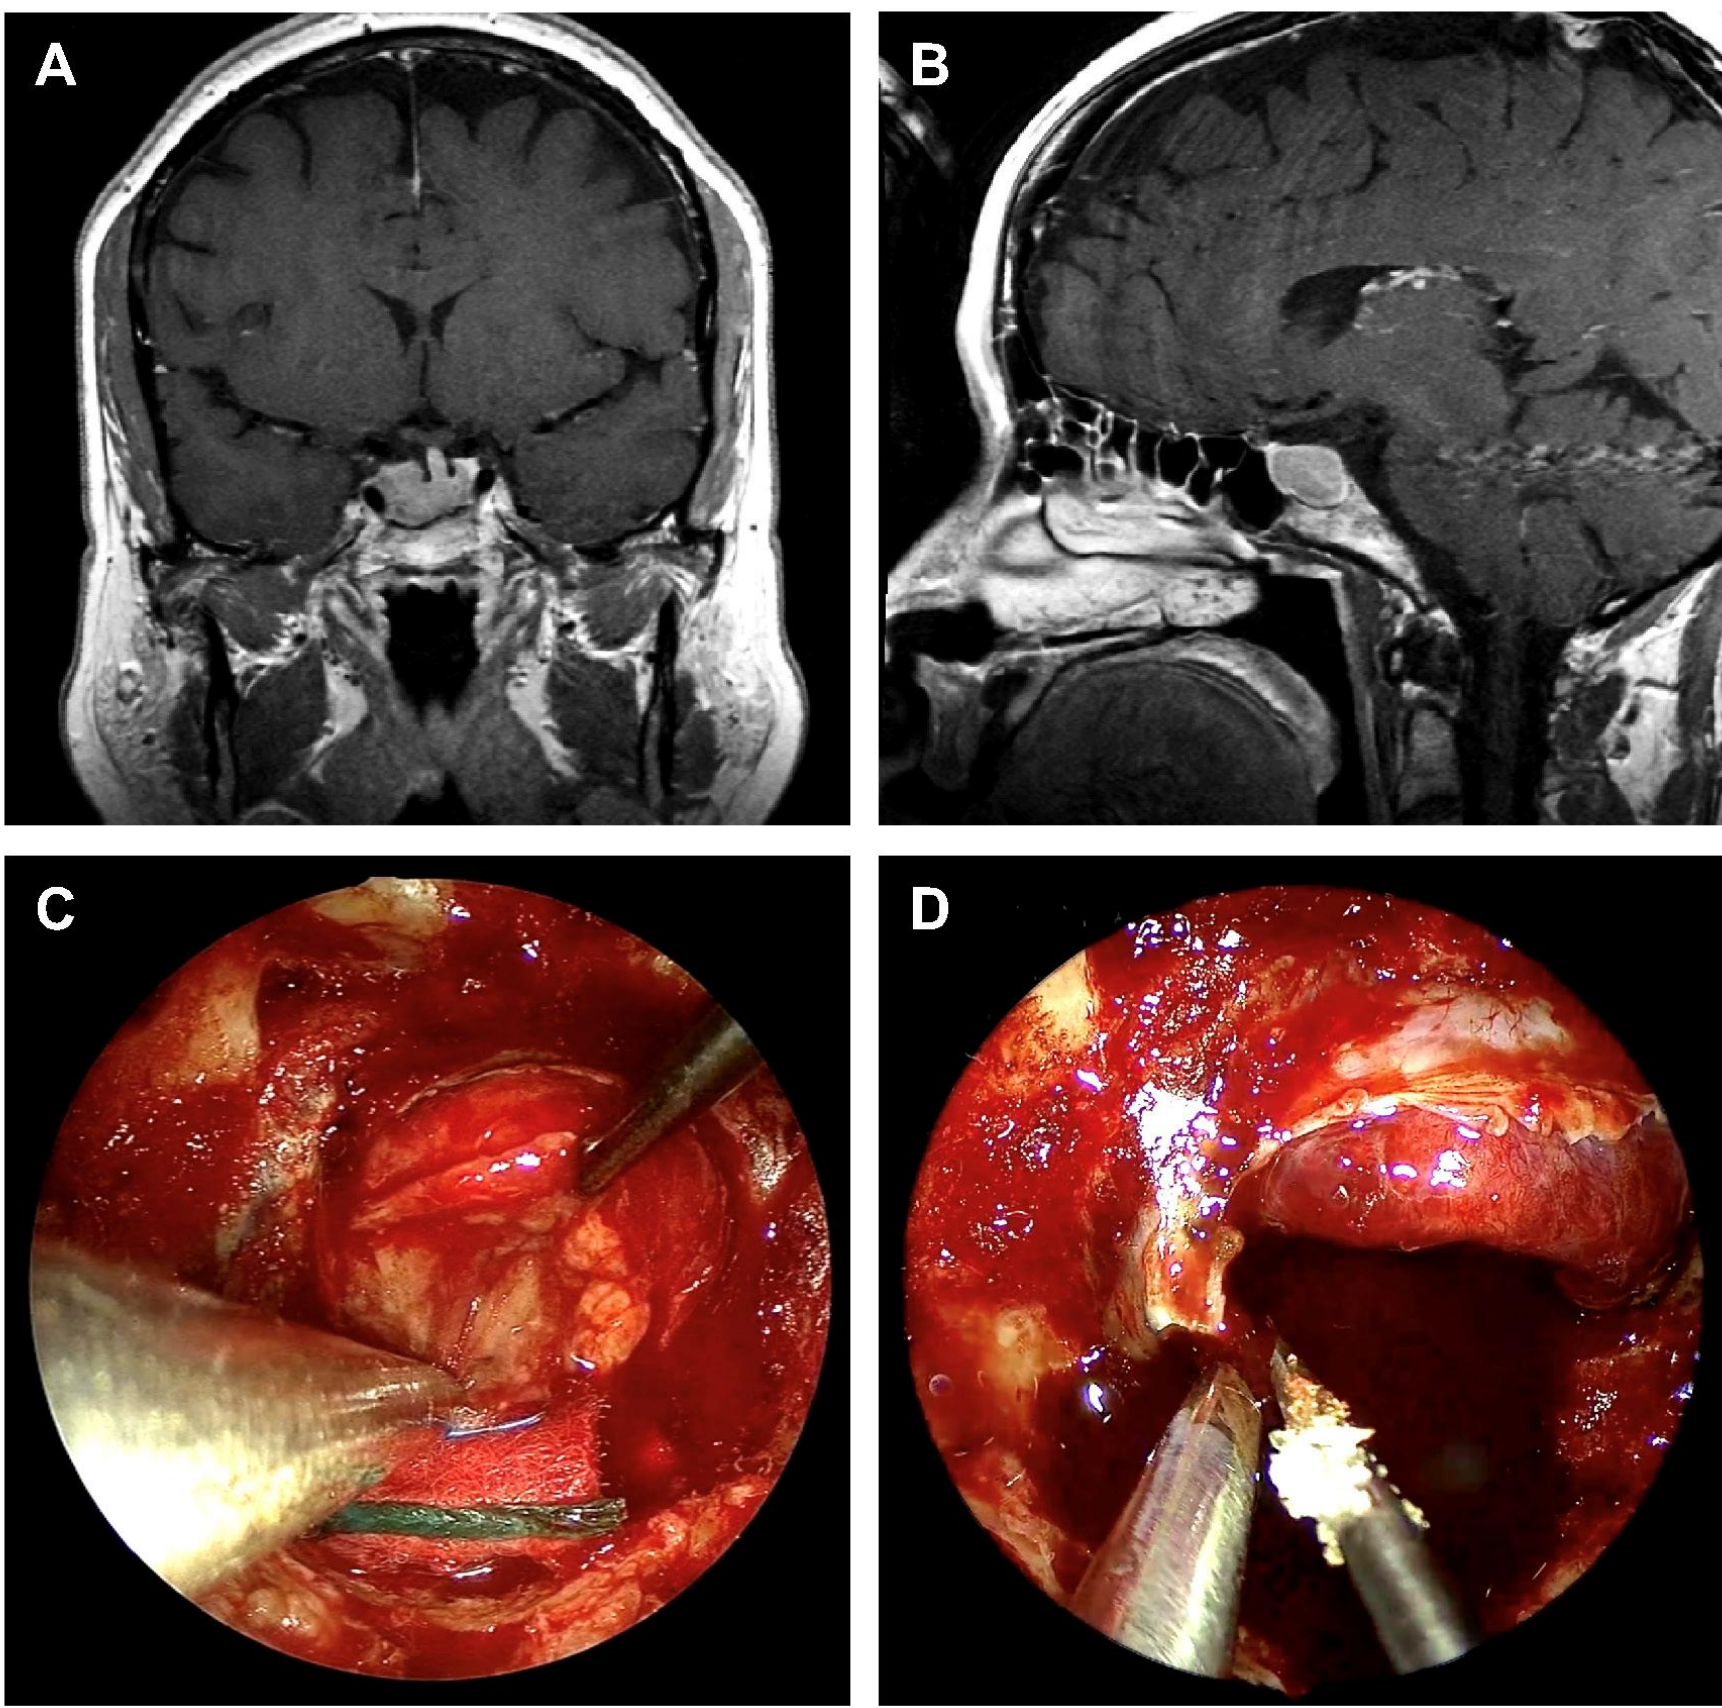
Endoscopic endonasal transcavernous surgery for resection of a pituitary adenoma with cavernous sinus invasion. (A) Coronal and (B) sagittal MRI studies demonstrate a hypoenhancing pituitary lesion with involvement of the right cavernous sinus. (C) The sellar component of surgical resection was performed involving central debulking and dissection of the tumor from the normal pituitary gland and the right-sided medial cavernous sinus wall. (D) Evidence of tumor invasion was identified along the medial wall of the right cavernous sinus, prompting transcavernous exploration and resection of the medial wall of the cavernous sinus, without evidence of frank cavernous sinus invasion.
